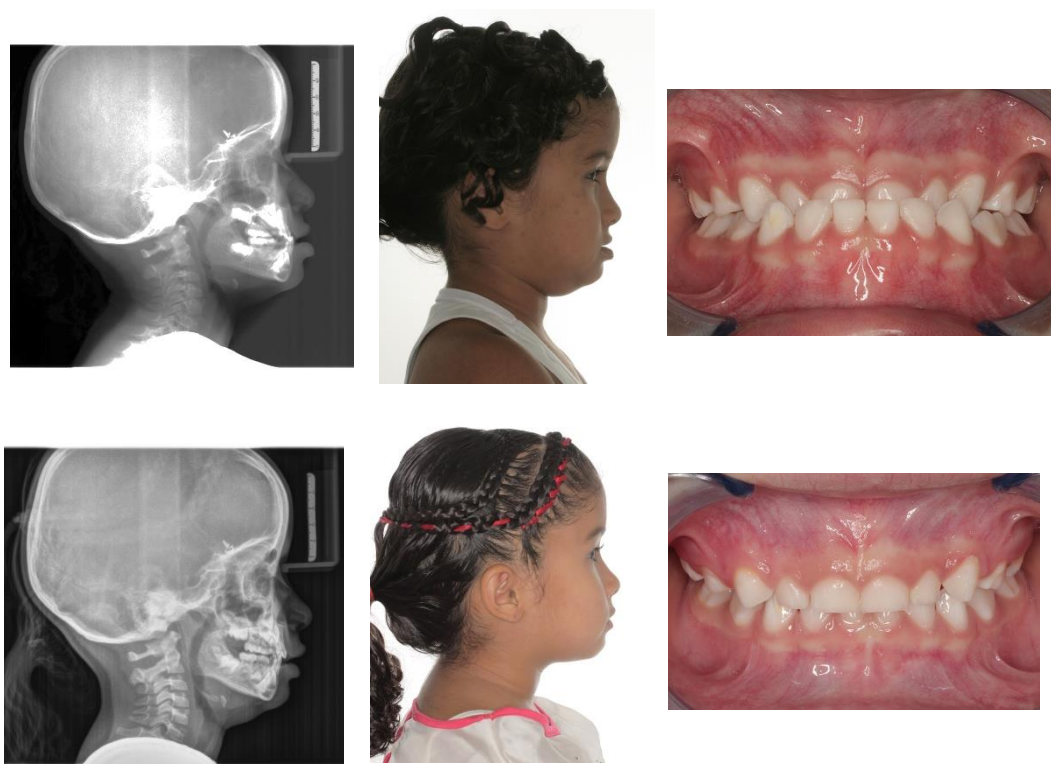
Cephalic X-ray, picture of facial profile picture and frontal occlusion of a girl without Down syndrome, before and after treatment.
